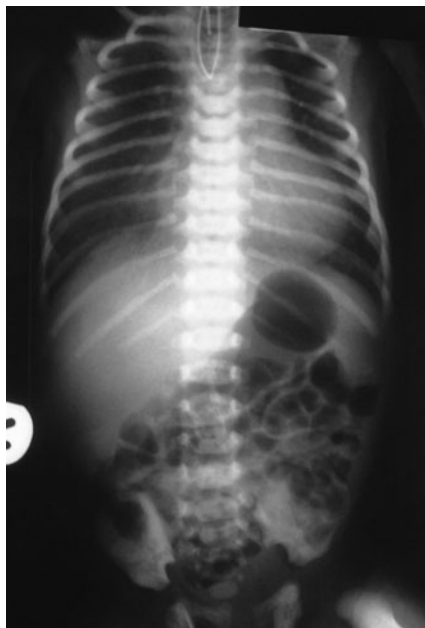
Chest x-ray film of a neonate with esophageal atresia and tracheo-esophageal fistula (TEF). Note the nasogastric tube coiled in the blind-ending upper esophagus. Air outlining intestinal loops below the diaphragm confirms the existence of a distal TEF.
